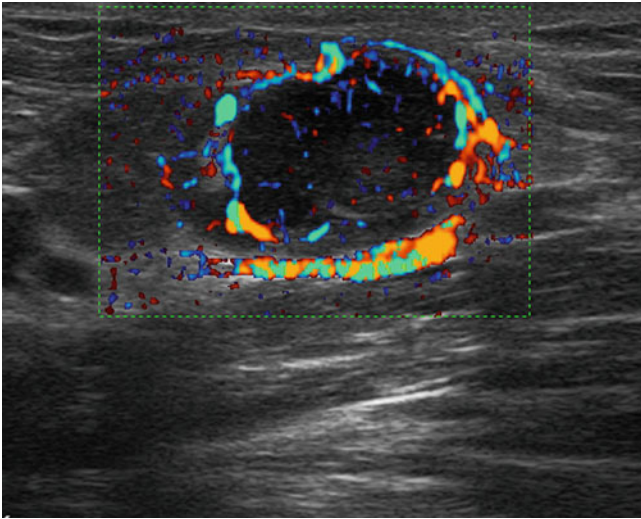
Metastatic lymph node of the groin. Intense, peripheral vascularization using directional power Doppler imaging
